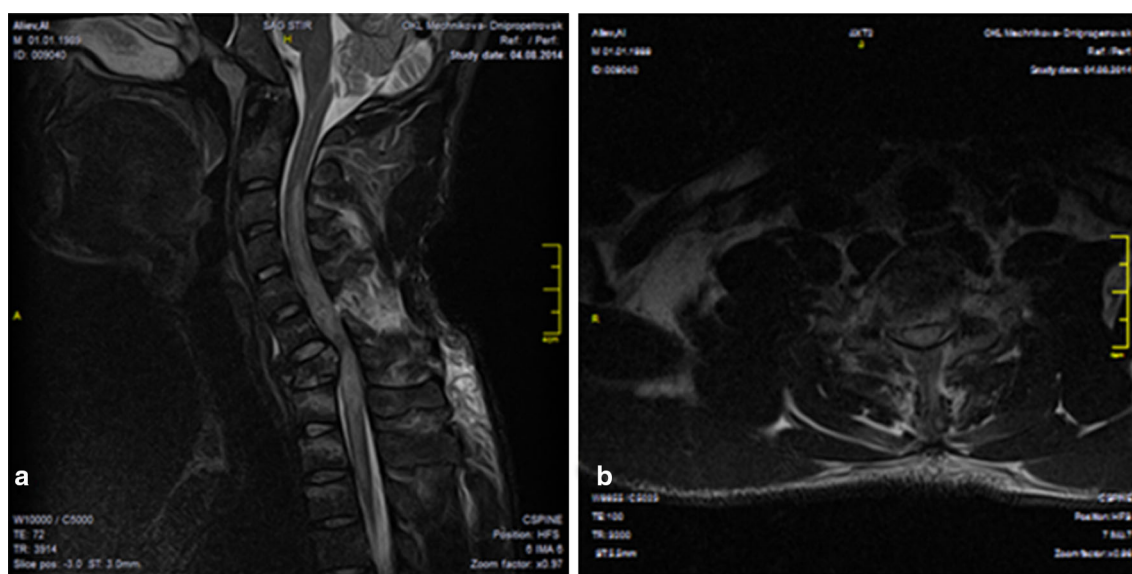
Magnetic resonance imaging of Case 3. Compression and comminuted fracture of C7; myelopathy at the level of C7; an apparent zone of edema and ischemia. a Sagittal view. b Axial view
